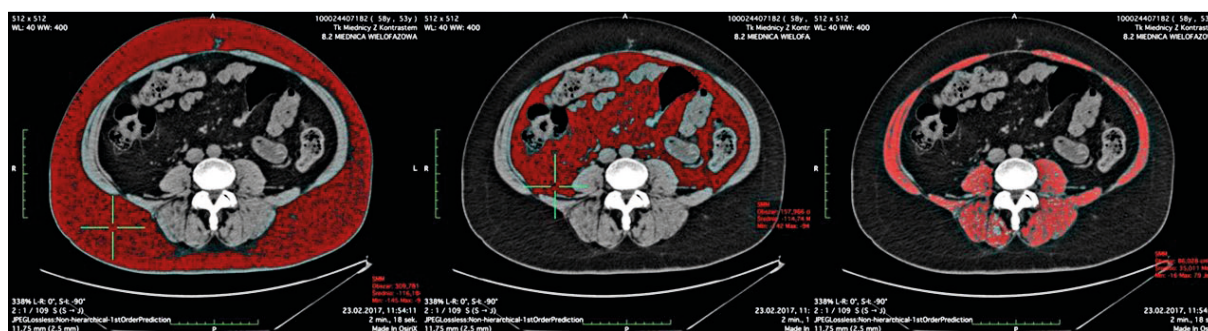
Example of computed tomography (CT) scans with the area-based densitometric quantification of tissues measured at spinal level L3 with regions of interest (ROI) containing (from left to right): A. subcutaneous adipose tissue (SAT) (threshold: -190 to -30 Hounsfield units [HU]); B. visceral adipose tissue (VAT) (threshold: -150 to -50 HU); and C. skeletal muscle area (SM, threshold: -30 to 150 HU)
